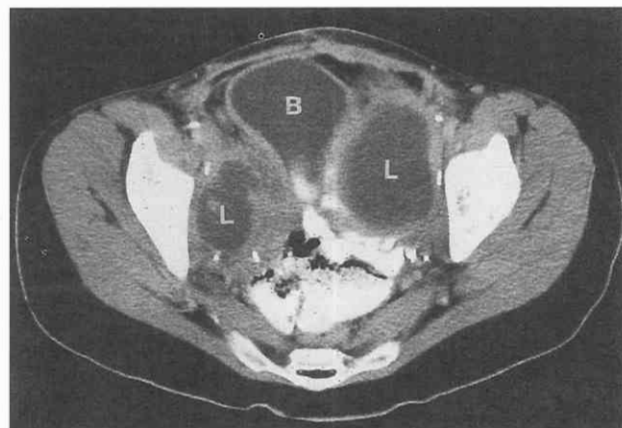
Lymphoceles. CT scan through bladder (B) shows bilateral large lymphoceles (L) surrounded by surgical clips from pelvic lymph node dissection.
